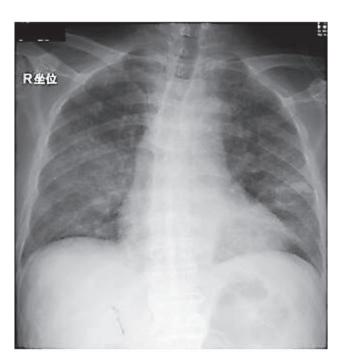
Chest X-ray on day 3 after admission reveals severe bilateral interstitial infiltrates.
